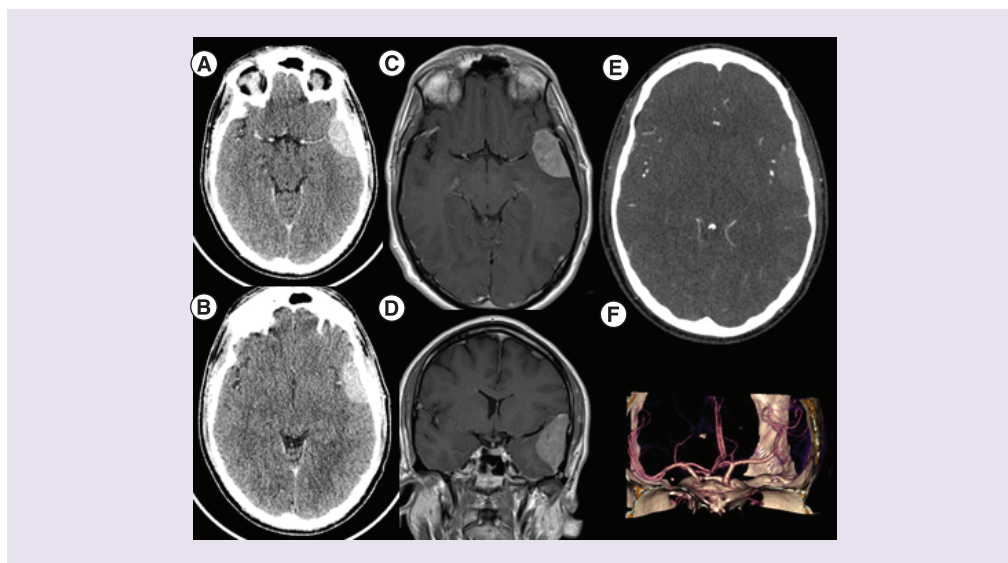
Pre-operative imaging. Axial-CT head with contrast (A and B) and axial (C) and coronal (D) MRI T1-weighted images with gadolinium revealing a homogeneously enhancing left pterional region tumor. Axial angio-CT head (E) and 3D angio-reconstruction (F) revealing the intrinsic relationship in between the left MCA branches and the lesion.
